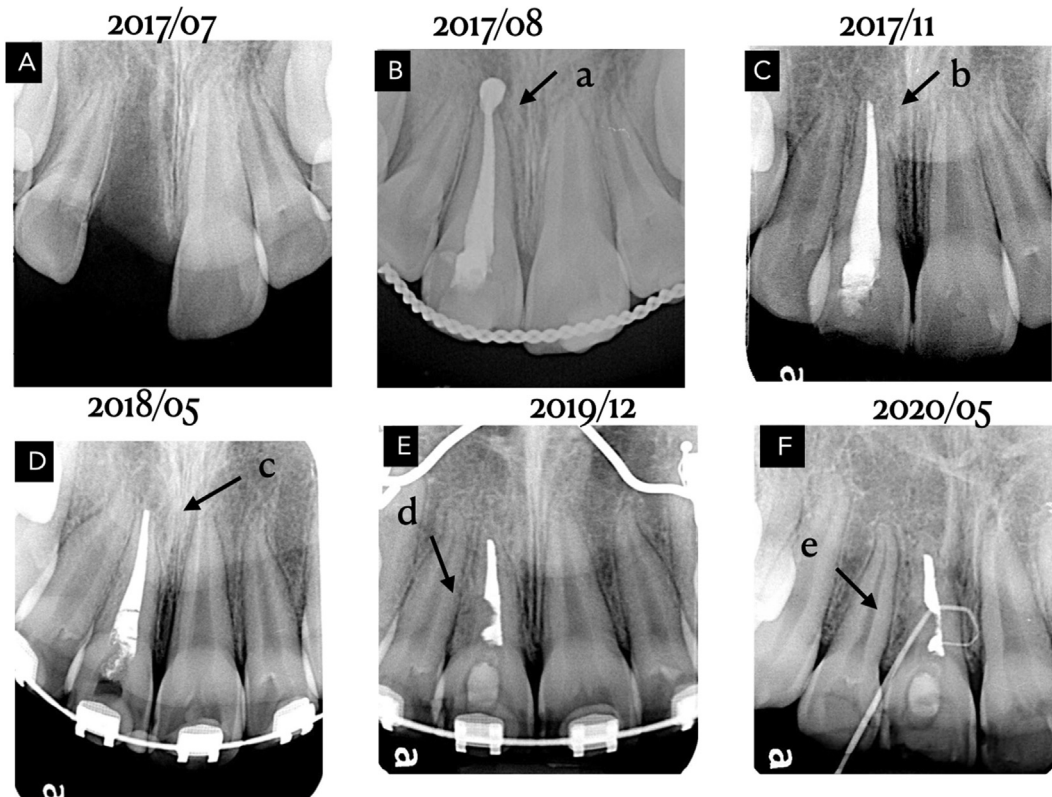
Periapical radiographs of the upper right central incisor. (A) The dental trauma injury was on the upper right central incisor (#11) with avulsion. (B) The canal was filled with Ca(OH)_2 cement for the purpose of apexification. (C) At the three-month follow-up, #11 exhibited an intact root surface, and the extruded Ca(OH)_2 material had undergone resorption. (D) The patient underwent orthodontic treatment. (E) After 19 months of orthodontic treatment, the tooth #11 middle root area exhibited external root resorption, and orthodontic treatment was stopped immediately. (F) The fistula originated from the resorption area.
